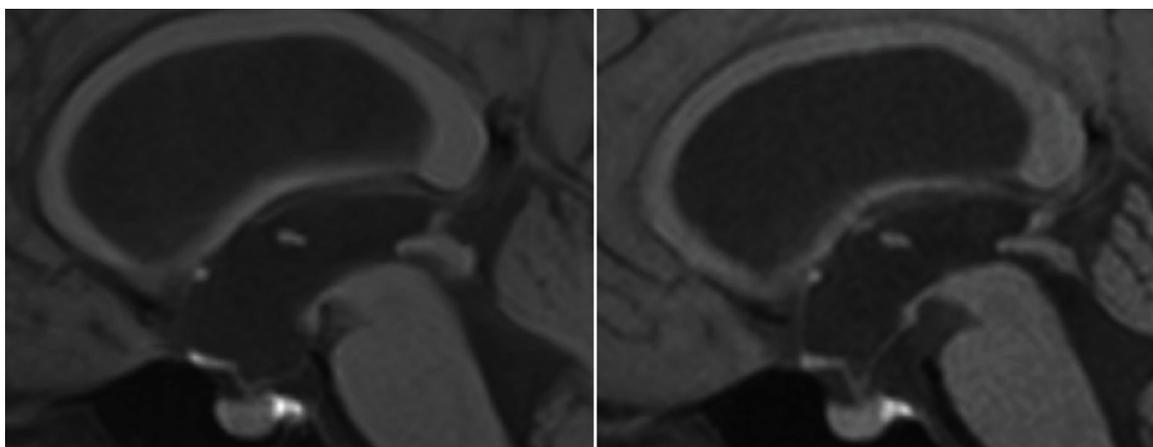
Preoperative MR imaging study demonstrating bowing of the third ventricle (left) and postoperative imaging showing correction of third ventricle morphology after successful ETV (right).
